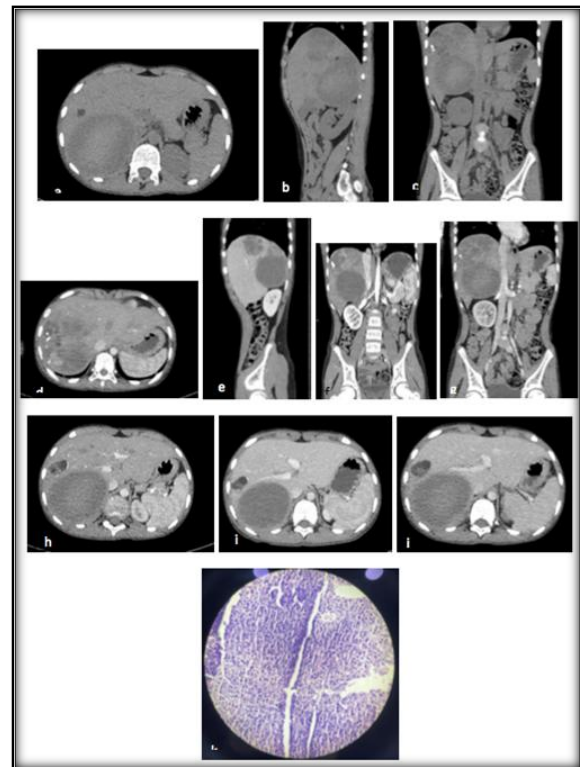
a-c: axial, sagittal & coronal plain CT images; d-g: axial, sagittal & coronal portal venous phase images show a large heterogeneously enhancing hypodense solid-cystic lesion in right lobe of liver in a 13 yr. old with weakness & weight loss complaints. Imaging and HPE (k) diagnosis were consistent with Hepatoblastoma; h-j: Incidentally, small well defined hypodense hemangioma was noted adjacent to hepatoblastoma which shows nodular arterial phase enhancement with centripetal venous phase filling.
